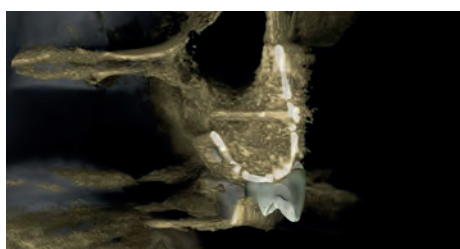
A cross sectional CBCT view showing the vertical bone regeneration
